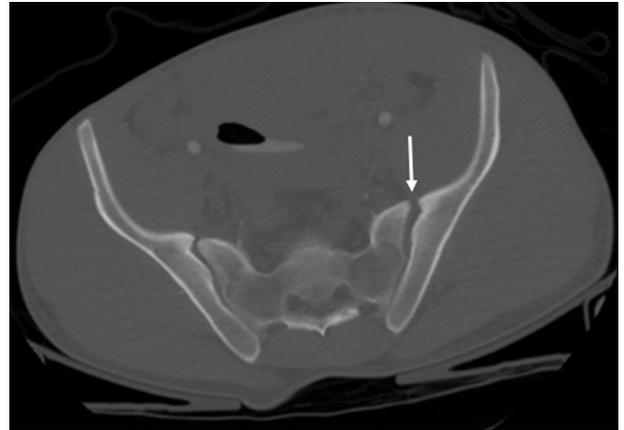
Axial CT of the pelvis in Grade II anteroposterior compression injury: anterior widening of left sacroiliac joint.
